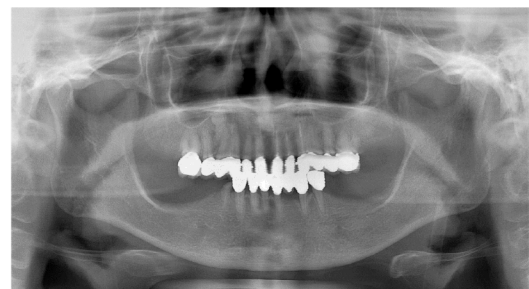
Pre-surgical panoramic radiograph on first visit.
